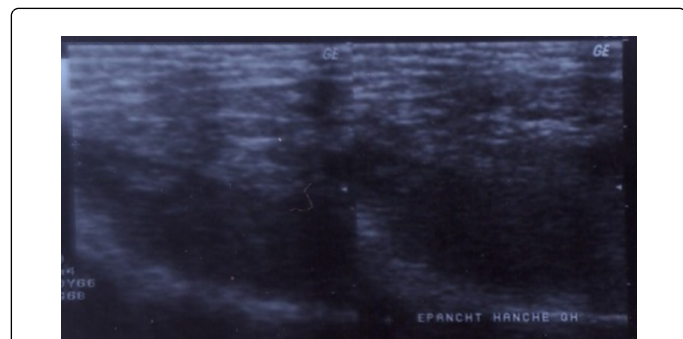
Ultrasound of the left hip- left coxofemoral joint effusion.
